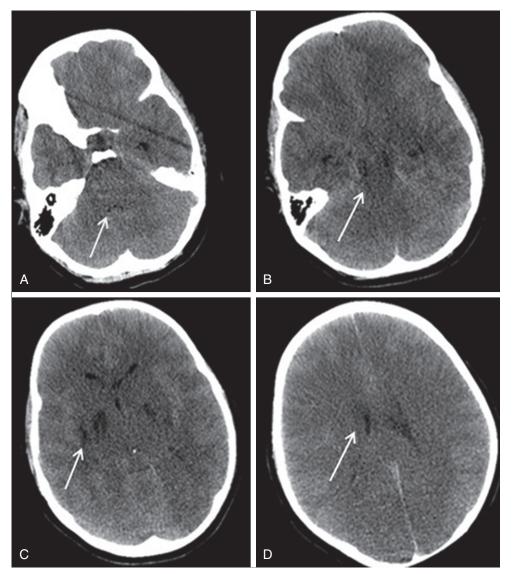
Near drowning/cardiac arrest; diffuse cerebral edema. Unenhanced axial CT images of a patient after cardiac arrest from near drowning delineate effacement of the fourth ventricle (*A*, *arrow*), effacement of the perimesencephalic cisterns (*B*, *arrow*), ischemic changes in the basal ganglia (*C*, *arrow*), and partially effaced lateral ventricles (*D*, *arrow*). On each of the images there is loss of gray/white matter differentiation and sulcal effacement.
